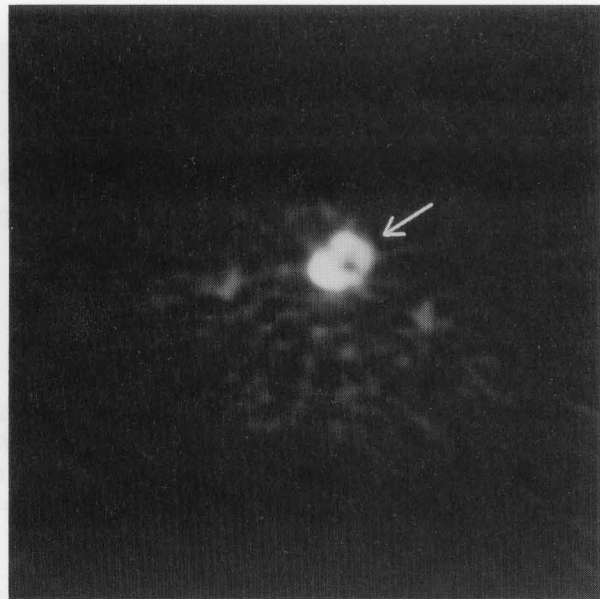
There is an intense focal uptake of FDG in the cranial scrotal region (arrow) on a transaxial section through the cranial portion of the scrotum. Note the ring-like uptake with a photon-deficient area in the central part.
